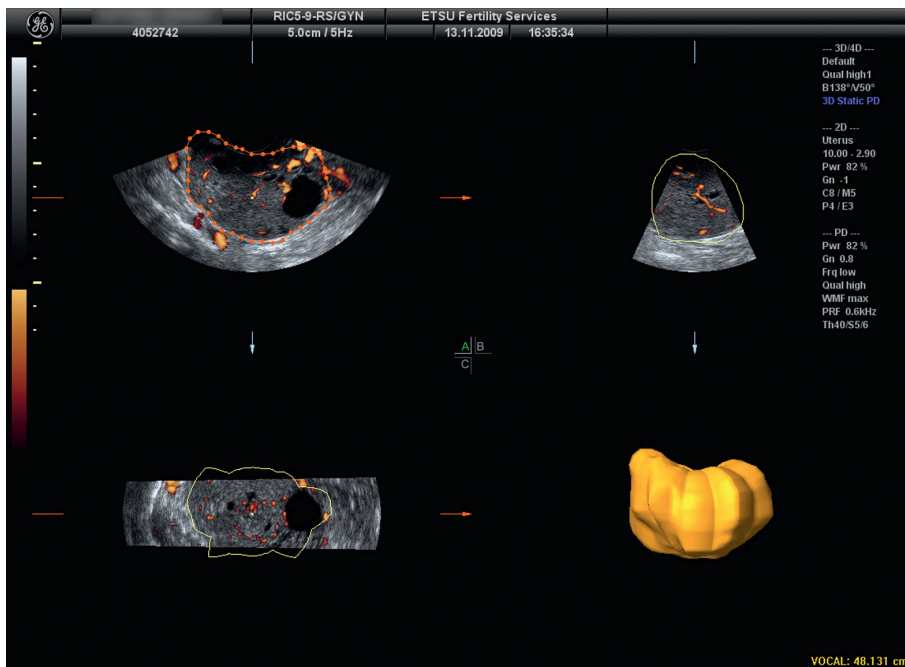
Rendering “power Doppler” scan of ovary to give an accurate volume of that structure.
